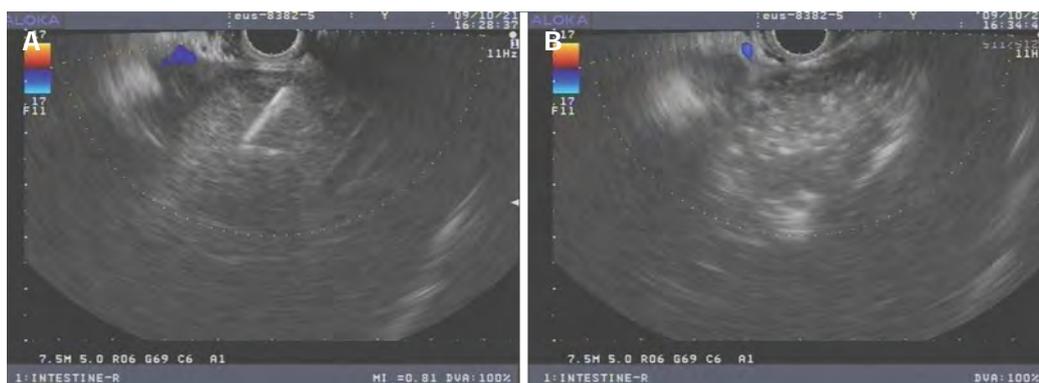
Endoscopic ultrasonography image of hepatic tumor. A: During ethanol injection; B: Hyperechoic appearance after ethanol injection.
